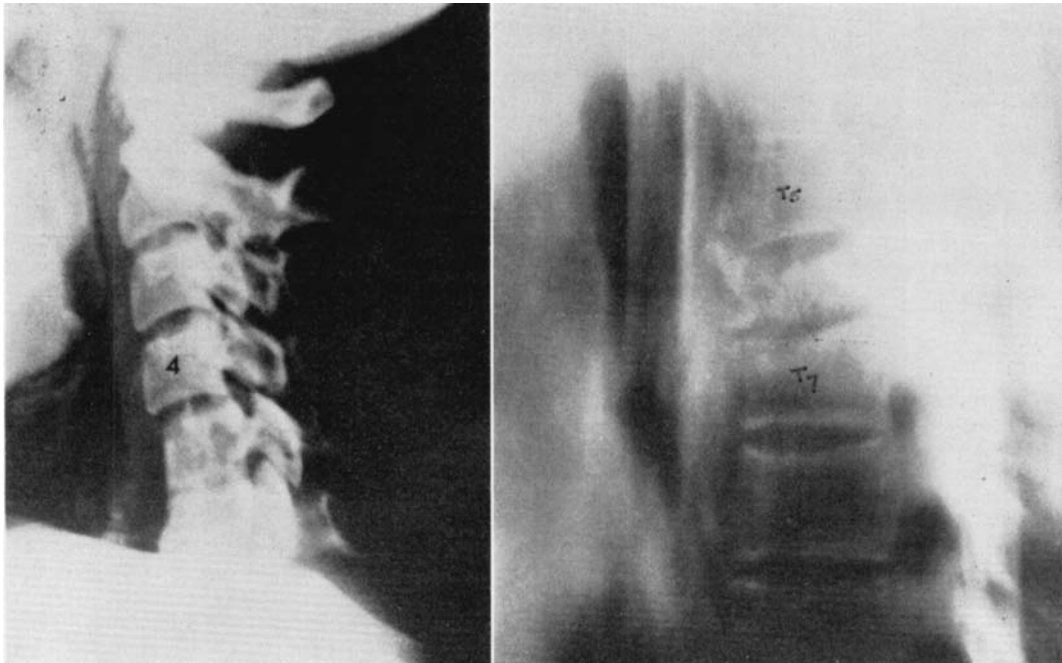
(Case 4). A. Right—x-ray (tomogram) of thoracic spine taken 4 weeks following injury. This tomogram adequately demonstrates comminuted fracture of T_6 vertebral body plus fracture of the inferior angle of T_5 and wedging of the body of T_7 . Dislocation of T_5 vertebral body on T_6 was more evident on the plain films. B. Left—x-ray of cervical spine, taken 4 weeks following injury, reveals compression fracture of C_5 with subluxation of C_4 vertebral body on C_5 .
